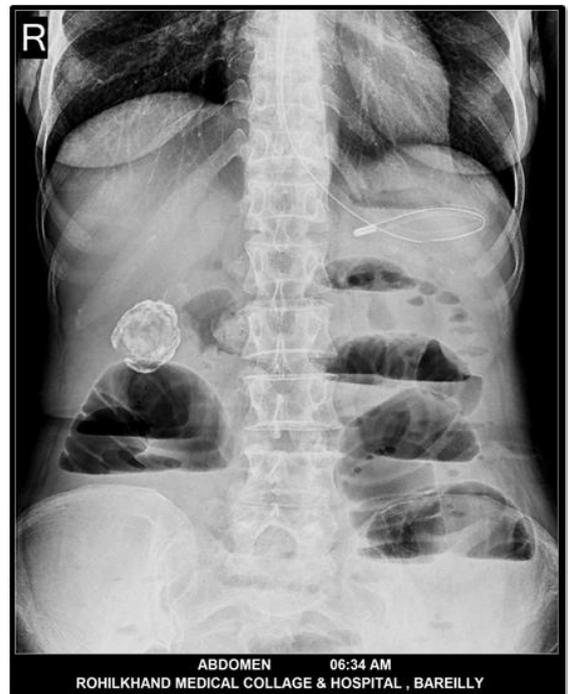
On x-ray abdomen erect film, multiple air fluid levels are seen, likely suggestive of intestinal obstruction. Also, there is calcified opacity in right upper quadrant (likely cholelithiasis) as an incidental finding.
